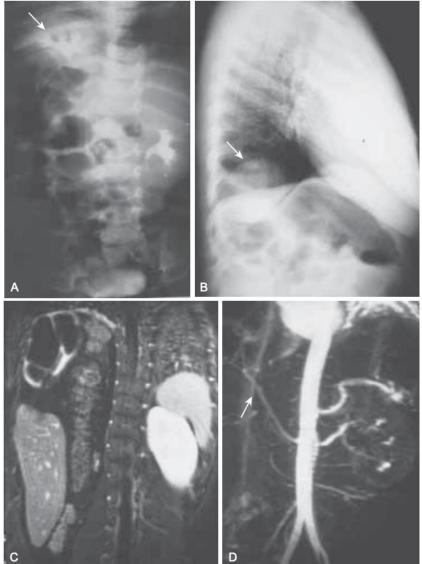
Thoracic renal ectopia (A-intravenous pyelogram shows a right thoracic kidney (*arrow*) and left orthotopic kidney. B -chest radiograph demonstrates right diaphragmatic eventration and a right intrathoracic kidney (*arrow*). C- magnetic resonance urogram shows coronal T1 fat saturation after contrast images of poorly functioning right hydronephrotic kidney located superior to the liver and inferior to
